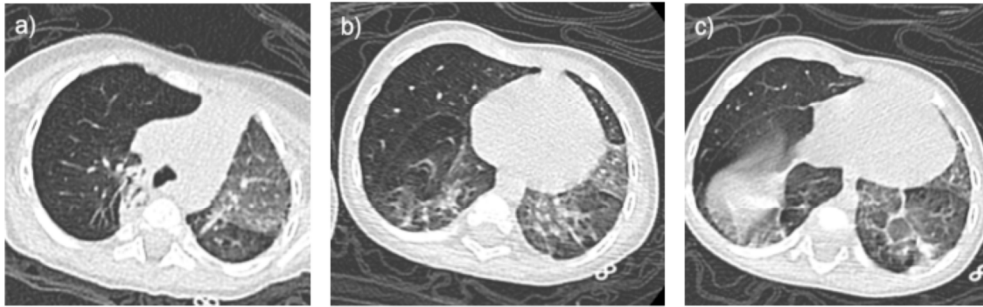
Case 2: Axial chest computed tomography images of the upper (a), middle (b) and lower (c) zones at four months of age. Right upper and middle lobe hyperinflation with patchy ground glass opacification and atelectasis are present within the left lung and right lower lobe.
